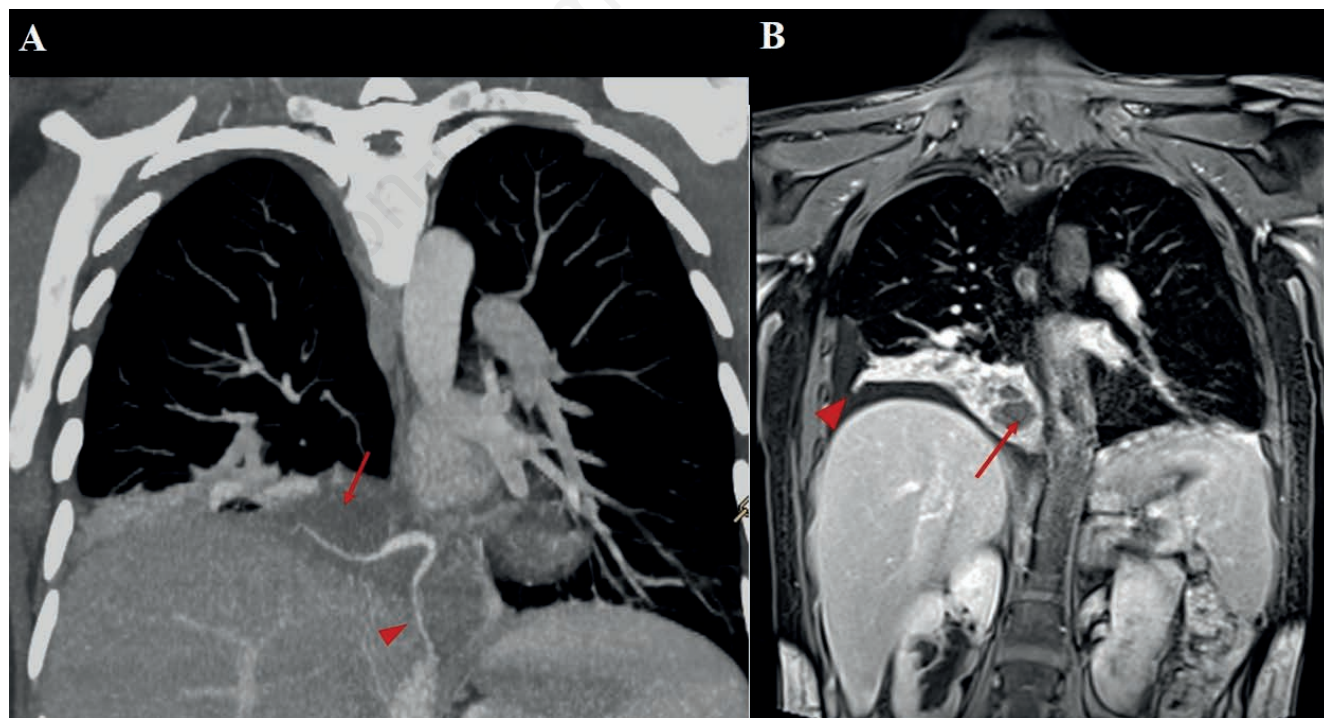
A) Maximum intensity projection paracoronar reconstruction of the computed tomography scan: aberrant artery (arrowhead); lung consolidation in the right lower lobe (arrow); B) magnetic resonance coronal image: pleural fluid collection (arrowhead); right lower lobe consolidation (arrow).
